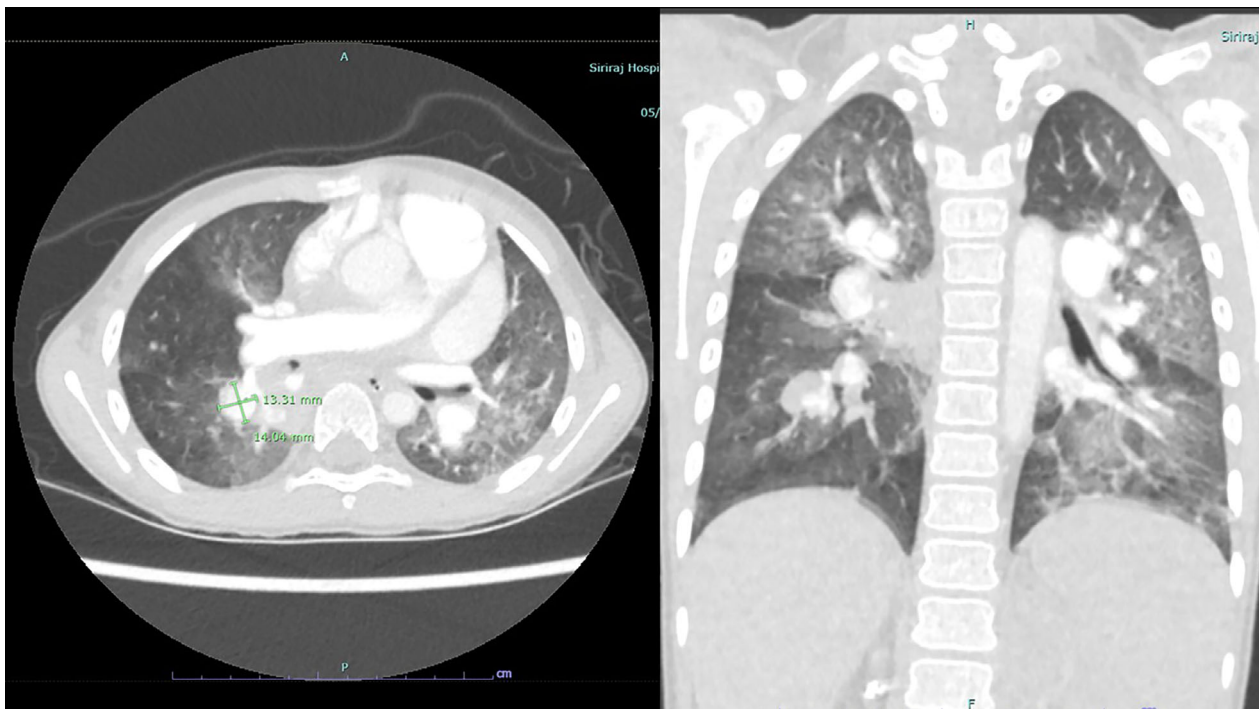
Computed tomography angiogram showed multiple outpouching lesions at bilateral segmental pulmonary arteries; internal eccentric filling defect suggested partially thrombosed aneurysm without active contrast extravasation or calcification
